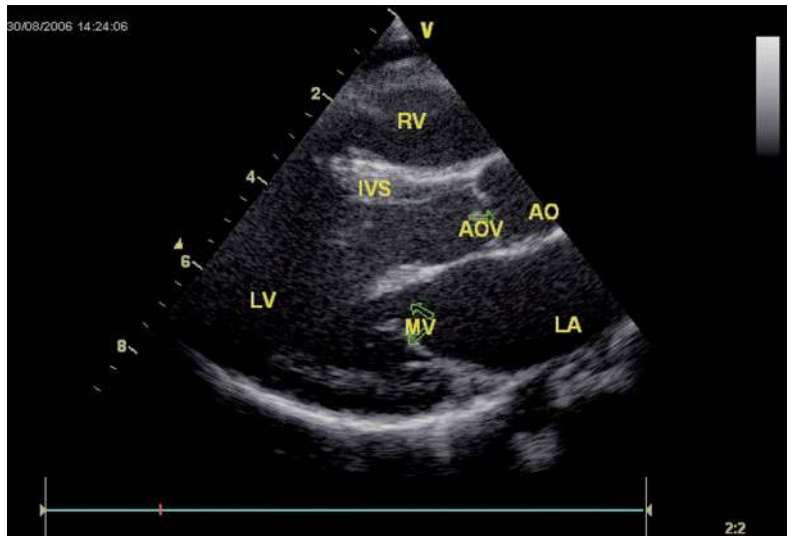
Parasternal long axis view in a normal patient
